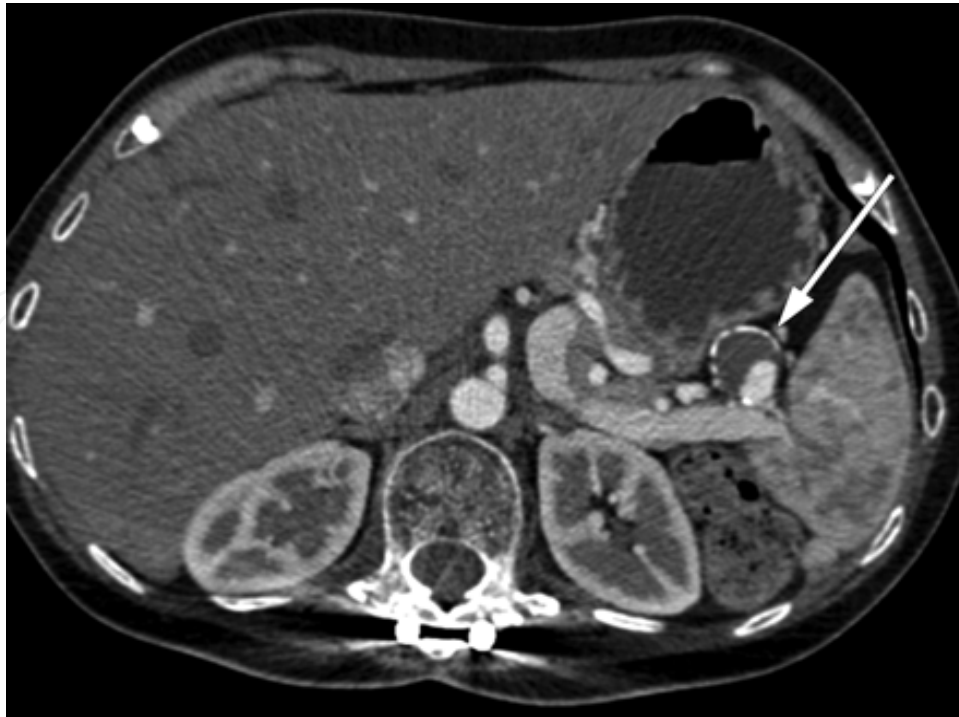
A Peripherally calcified, and thrombosed splenic artery aneurysm, (CT view)
